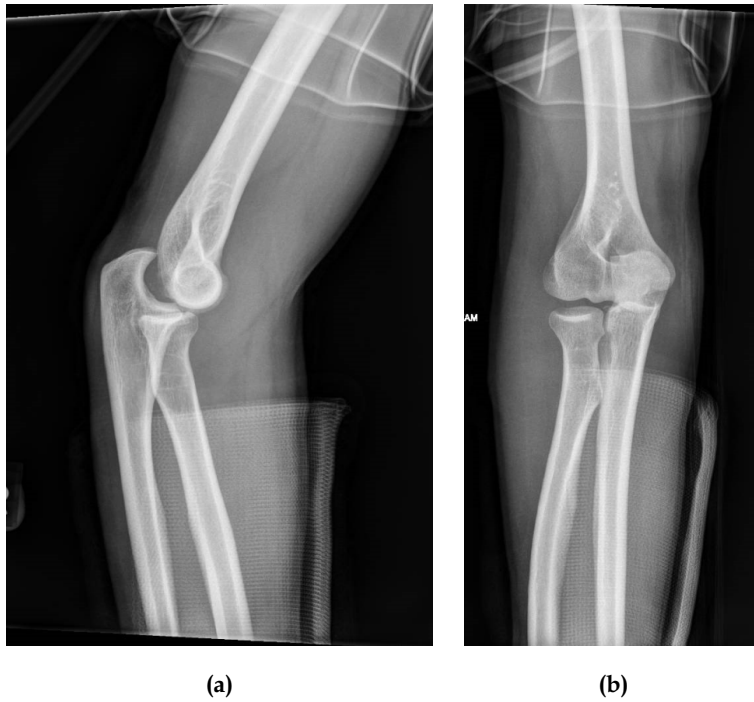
(a) Anterior view of radiograph of the right elbow dislocation and (b) Lateral view of radiograph of the right elbow dislocation.
